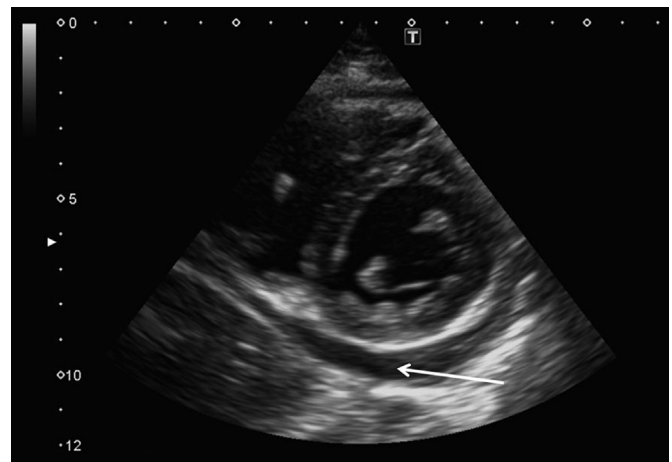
Pericardial effusion (arrow) on echocardiography in a patient with systemic arthritis. Adapted from the personal collection of the authors.
